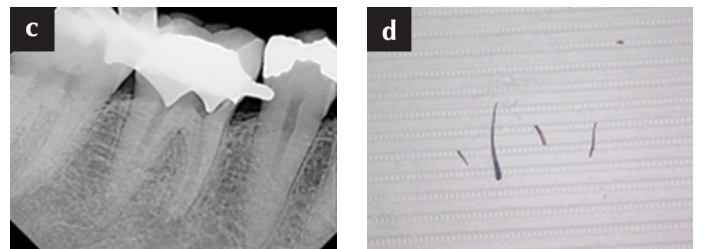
Tooth No. 30 was disassembled. Thermofil was used to obturate the tooth. Thermofil was removed using a Touch'n Heat tip (Sybron Endo) and a Hedstrom file (Sybron Endo) screwed into the remaining material. The separated file was removed using ultrasonics after staging with a cut-off tip No. 4 Gates Glidden Drill.
